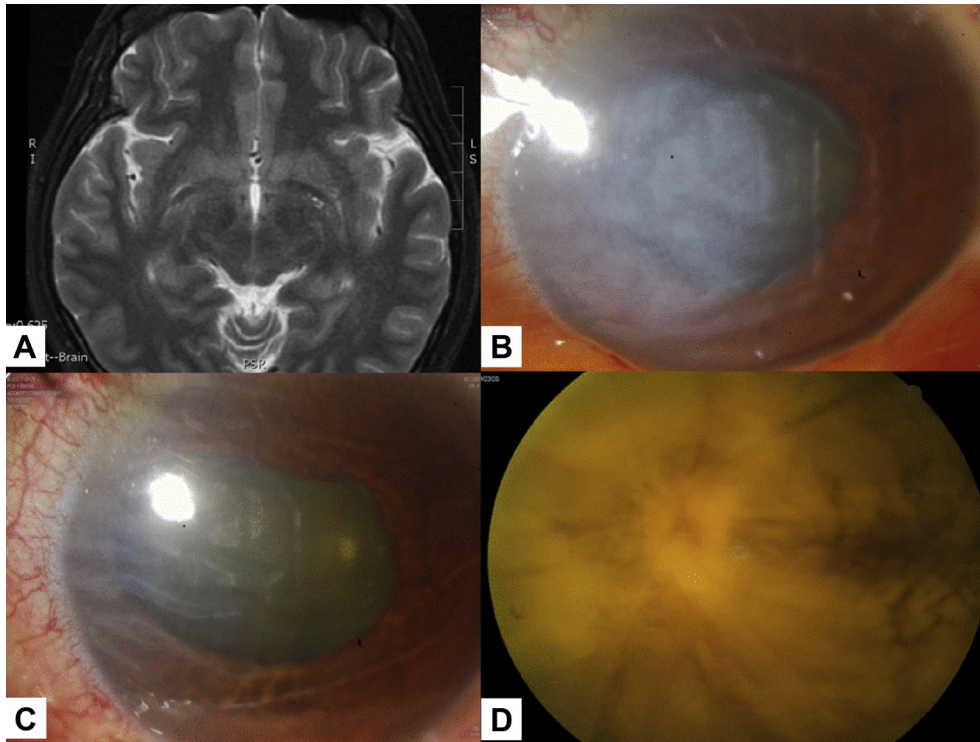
Case 1: (A) Brain magnetic resonance imaging (T2 FS) showing multiple small infarctions and multiple intracranial hemorrhages in the left cerebral hemisphere. (B) The cornea of the left eye 1 day after the injection became edematous. (C) The corneal edema of the left eye is markedly improved 3 weeks after the injection. (D) Fundus photography of the left eye 3 weeks after the injection showing total exudative retinal detachment with retinal atrophy.
